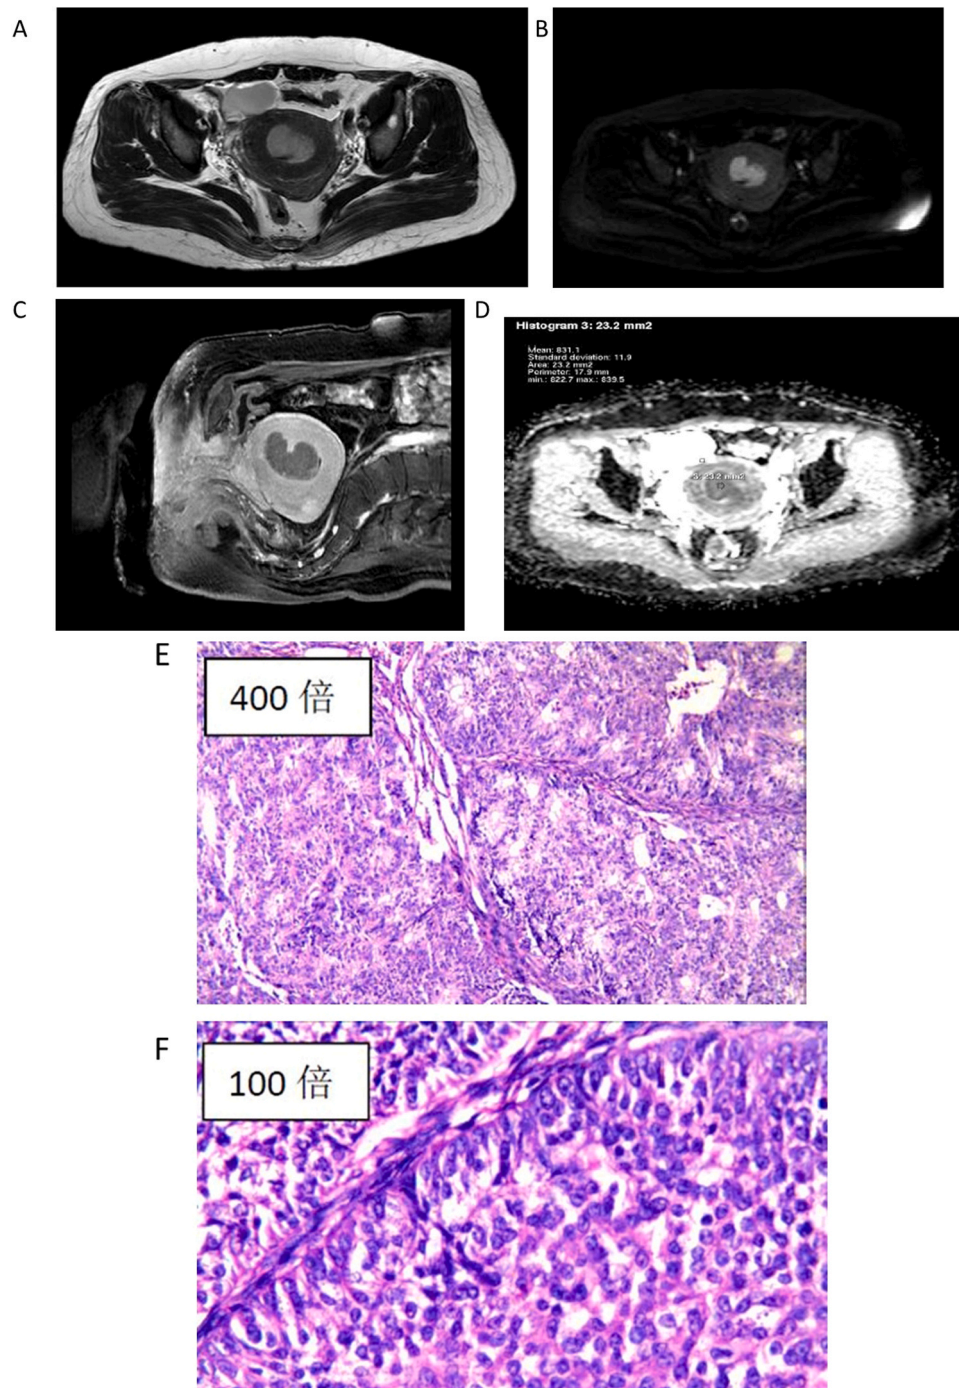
a-b: Transection a T2WI in visible crumb intrauterine lesions show slightly higher signal, sagittal mild enhanced visible lesions improved significantly lower than that of myometrium, infiltrating muscular layer depth is less than 1/2. Fig. 1c-d: Diffusion weighted imaging (DWI, can b=1000 s/was), the lesion was significantly high signal, ADC is low signal, the average ADC values= $0.721 \times 10^{-3} \text{mm}^2$. Fig. 1e-f: Endometrioid adenocarcinoma, superficial muscle invasion (< muscle 1/2), grade II (moderately differentiated), lymph node negative.
